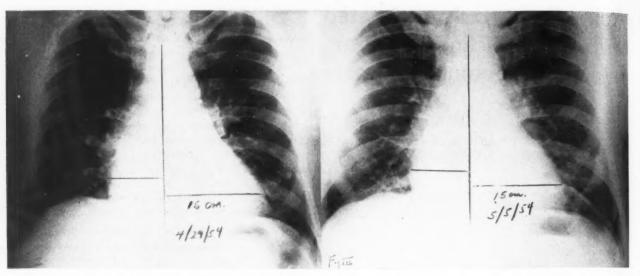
X-ray showing some precordial effusion. Transverse diameter of cardiac silhouette 16 cm.
